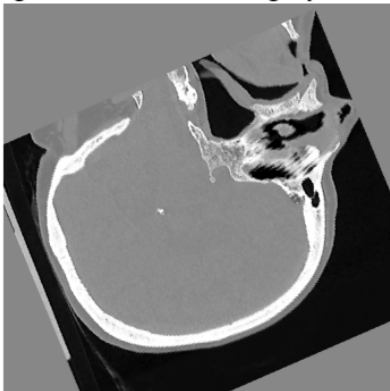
Registered conventional CT and ZTE image in the anatomical MRI space. (a) Conventional CT and the corresponding (b) ZTE image after preprocessing, registration and resampling.
